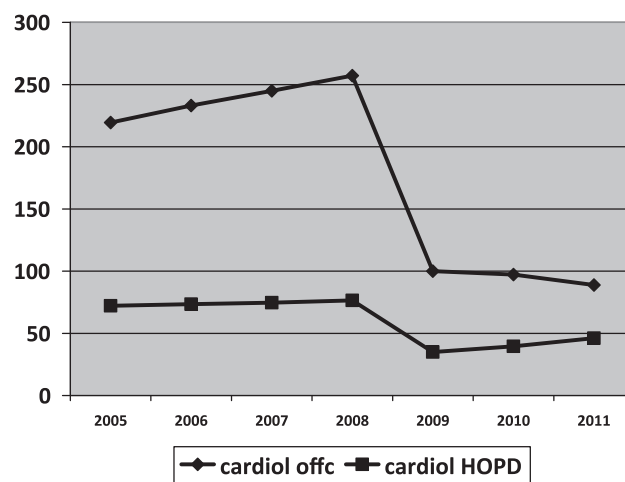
Outpatient echocardiography performed by cardiologists in the Medicare fee-for-service population, 2005 to 2011. The vertical axis shows the rate per 1,000 Medicare beneficiaries. Cardiol off = examinations performed by cardiologists in their private offices; cardiol HOPD = examinations performed by cardiologists in hospital outpatient facilities.
